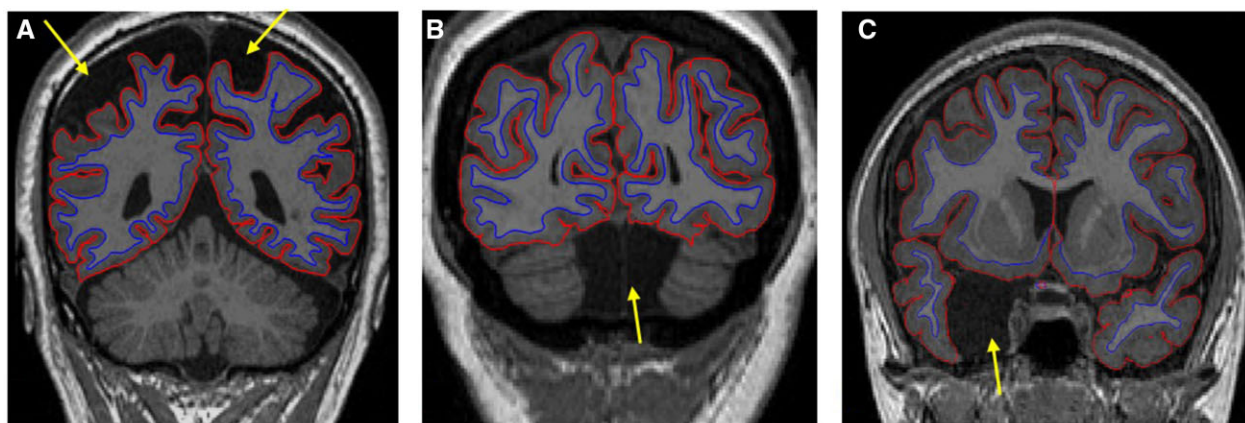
Examples of macroscopic brain MRI anomalies in family members. (A) Marked enlargement of extra-axial CSF disproportionate to age-related atrophy. Unknown if cause is malformative or atrophic in origin (seen in $n = 2$ family members). (B) Mega cisterna magna with increased retrovermian CSF ($n = 1$). (C) Right hemisphere middle cranial fossa arachnoid cyst with mass effect on right anterior temporal pole ($n = 1$). Other anomalies (not shown) in family members include: (i) abnormal morphology of left cingulate ($n = 3$) including interrupted anterior cingulate, straightened morphology and branching of anterior cingulate; (ii) round lesion in branch of left anterior cingulate sulcus ($n = 1$); (iii) atypical sulcation in left hemisphere ($n = 2$), including extending of left superior frontal gyrus from precentral gyrus, ramus crossing superior temporal gyrus to join sylvian fissure; elongation of back of sylvian fissure and radiating sulci; and (iv) asymmetrical hippocampi ($n = 1$) smaller left hippocampus.
